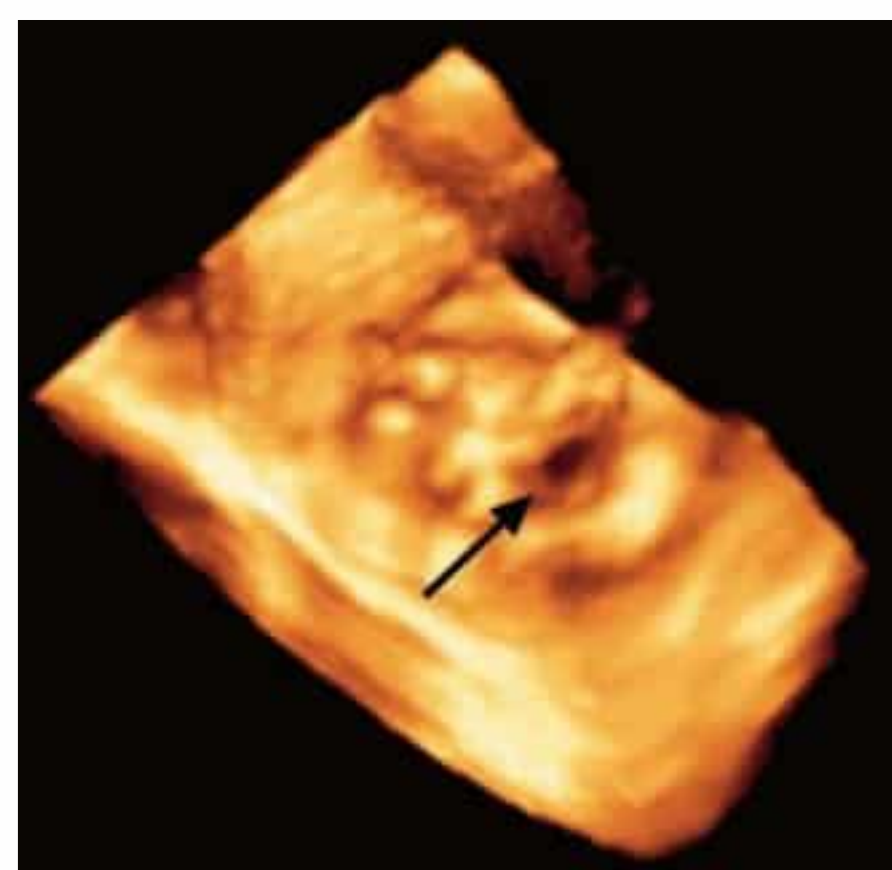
Mitral valve depicted by real-time 3D echocardiography. The bulging valve leaflets and markedly reduced orifice area (arrow) are viewed from the left ventricle.
